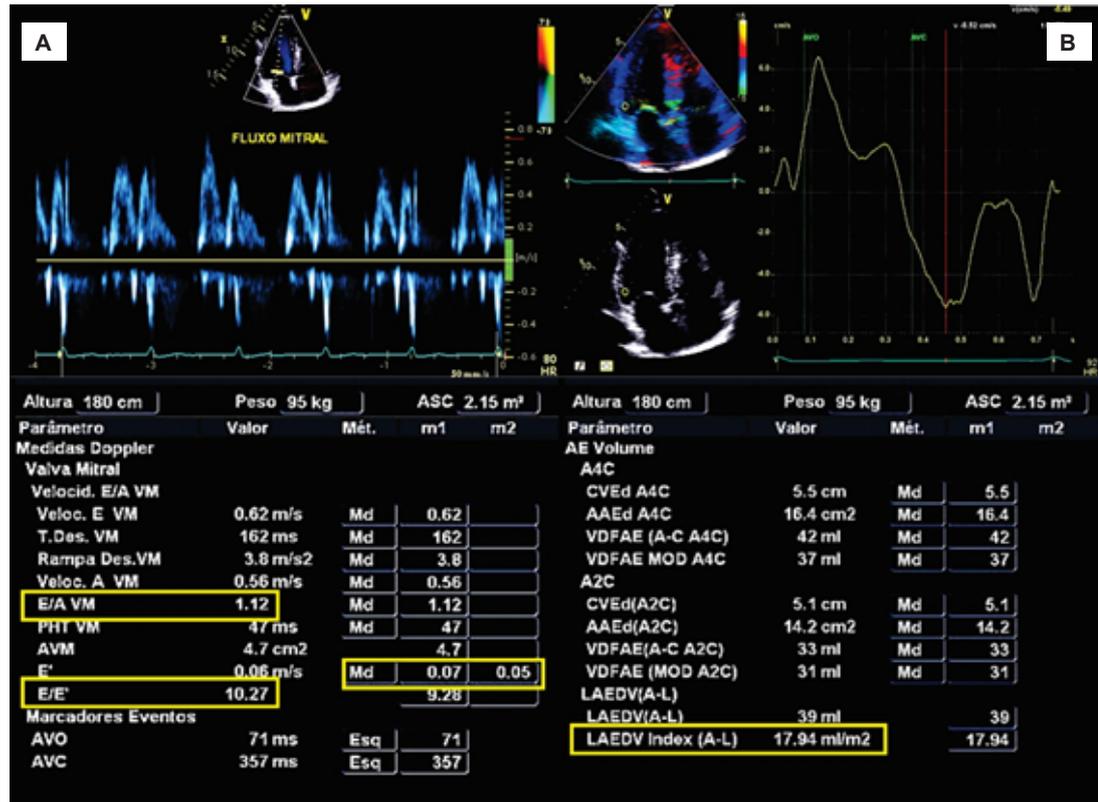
A) pulsed Doppler curve of mitral valve; B) tissue Doppler curve of mitral lateral annulus. E/A VM: mitral valve E/A ratio; LAEDVindex(A-L): left atrium indexed volume.
